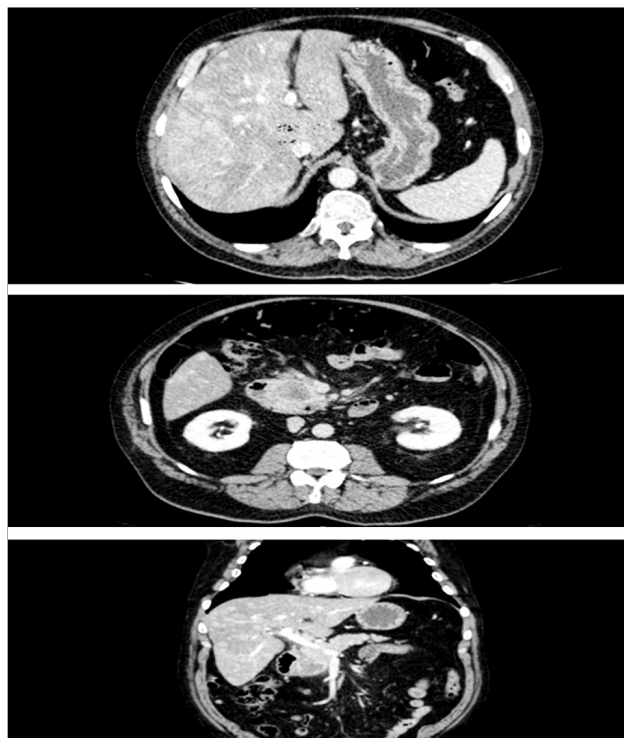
CT scan of patient
